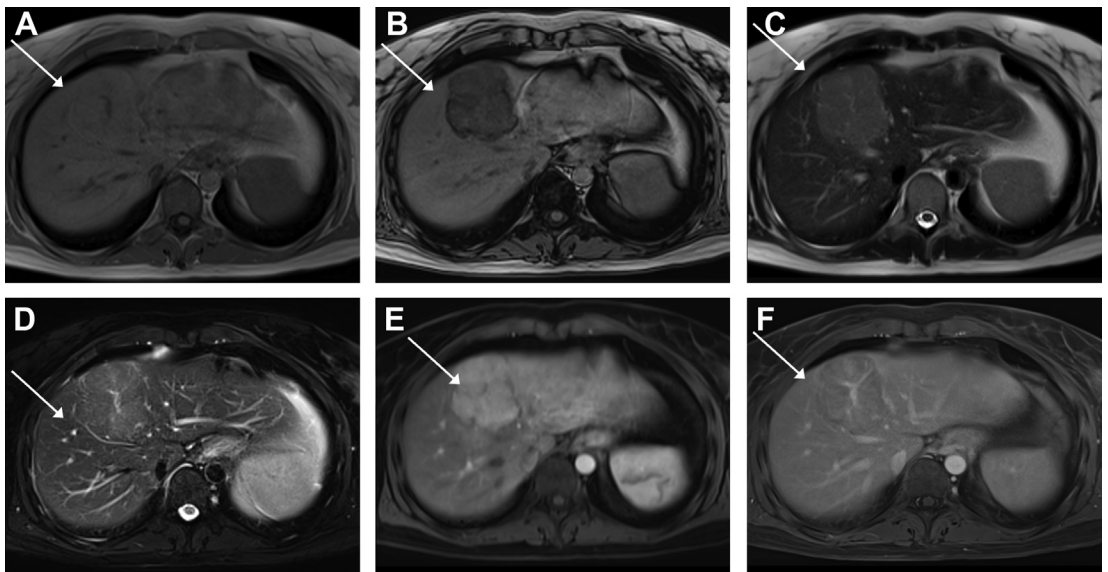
Example of steatotic focal nodular hyperplasia. Lobulated lesion with homogeneous dropout of signal on the T1-opposed-phase-weighted image (A+ B), with otherwise typical features of focal nodular hyperplasia on T2-HASTE (C), T2-weighted fat-saturated image (D), arterial phase (E), and delayed phase (F).
